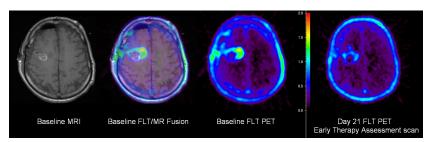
FLT PET images acquired from an 81 year-old male with right frontal lobe GBM at baseline and at early therapy assessment (21 days after therapy initiation). Image color indicates FLT uptake in SUV, which is decreased early in the therapy course.
